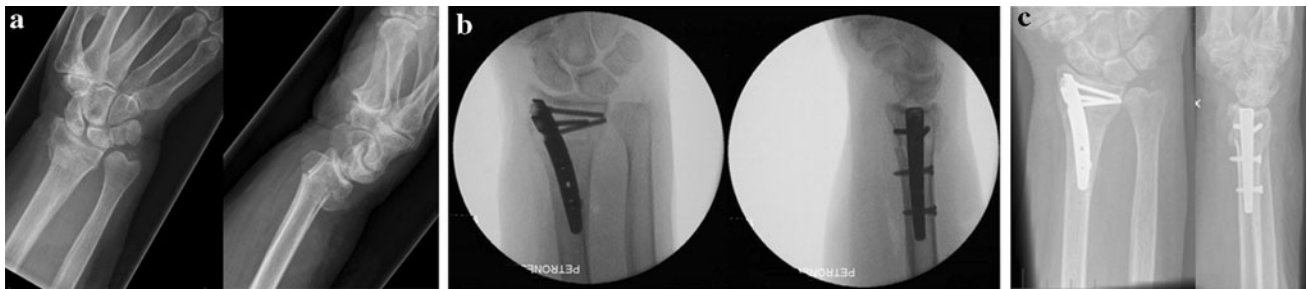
a X-rays of the left wrist in an 85-year-old female, after she slipped on a carpet and fell on her hand. b Anteroposterior and lateral radioscopic view during surgery, after positioning the Micronail®. c Control X-ray of the wrist after 16 weeks of follow-up
